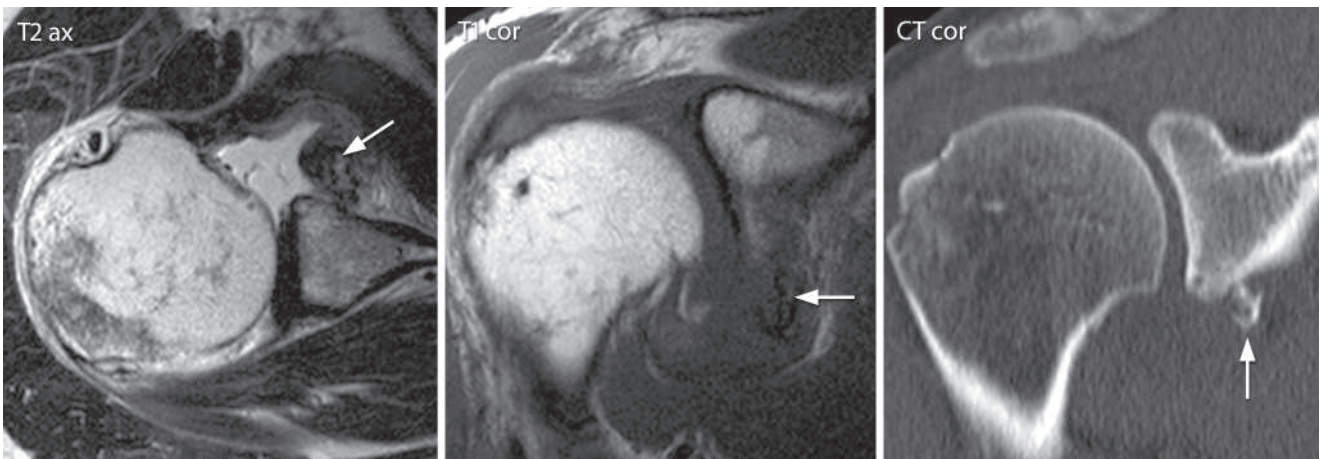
Classic Bankart lesion with torn anteroinferior glenoid rim (arrows). The bony component is best visualized on CT. CT is warranted for maximum sensitivity to any osseous fragments, in selected cases, although the clinical relevance of such fragments is inconsistent.
